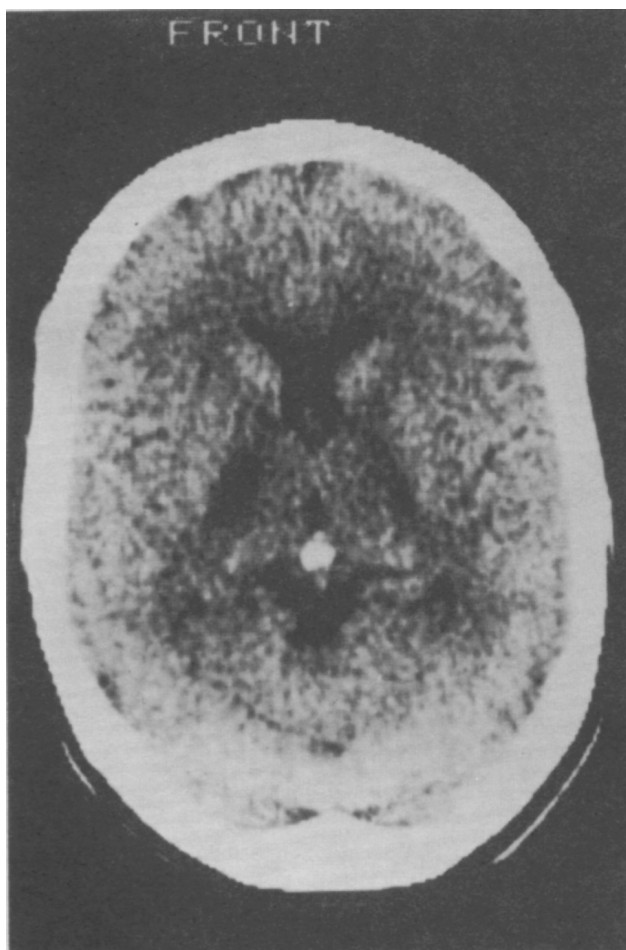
CT head scan of Case 2 showing an area of low attenuation adjacent to the right internal capsule.
